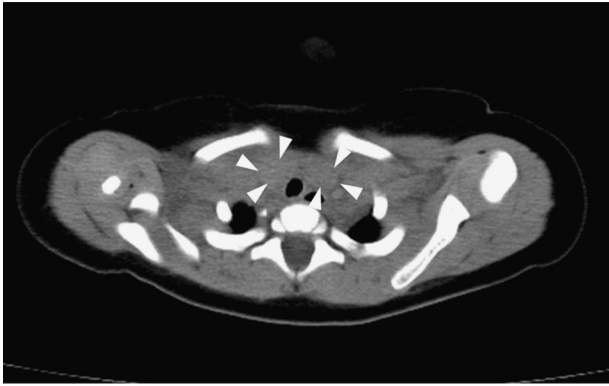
Postmortem computed tomography image of the neck. A horizontal image shows bilateral, solid nodules (surrounded by white arrowheads) anterolateral to the cervical trachea and immediately inferior to the thyroid gland.
